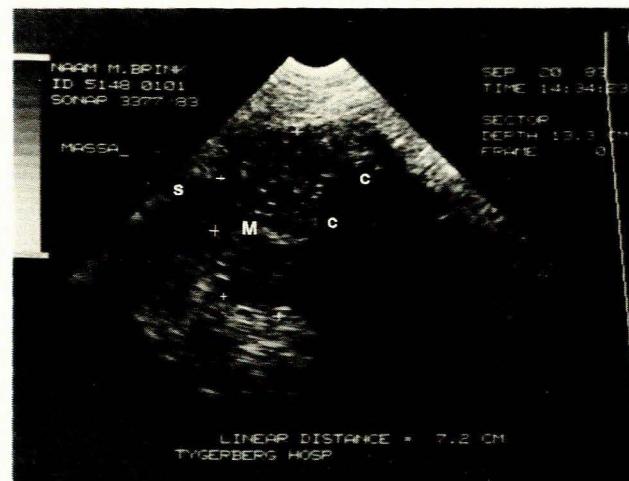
Sagittal ultrasonogram of left hypochondrium (M = mass; C = sound attenuated by calcific wall; S = spleen).
